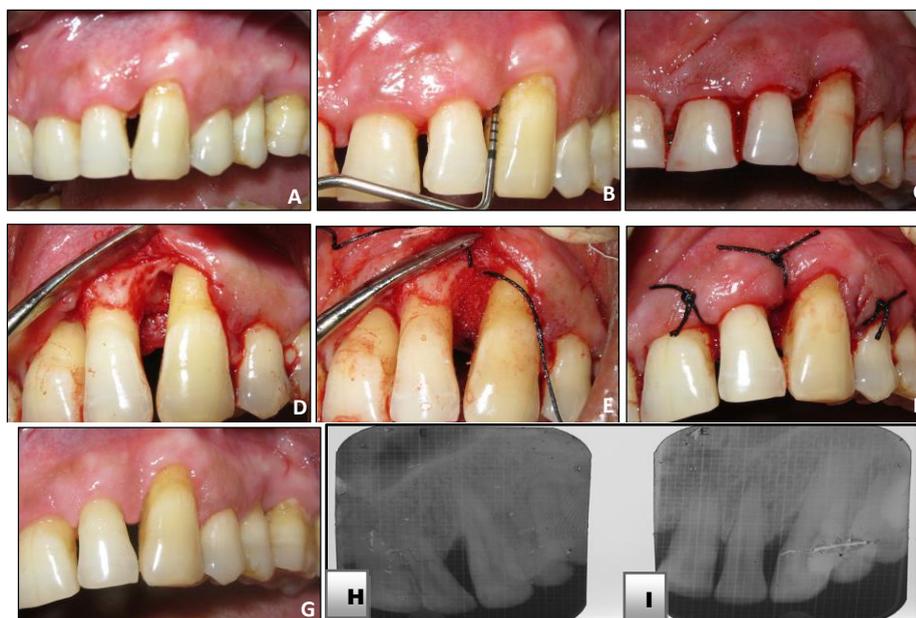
A: Pre-operative clinical picture B: Probing Depth: 10mm C: Incision D: Reflection and Debridement E: Graft (Bioactive glass) in place F: Sutures taken G: Post-operative clinical picture H: Pre-operative Radiograph I: Post-operative Radiograph
